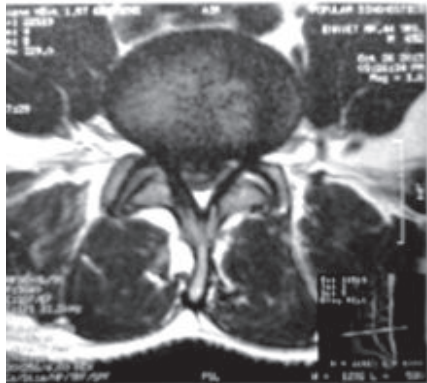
MRI of lumbar spine T2 weighted axial view at L4-5 level.
